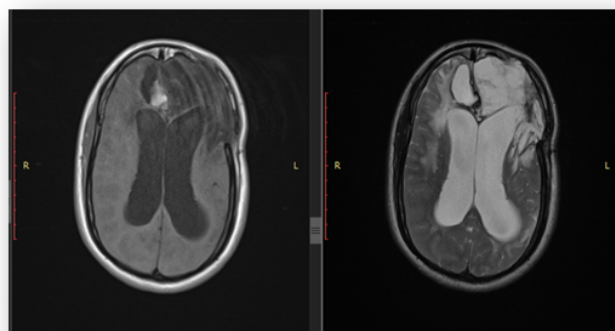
Magnetic Resonance Imaging Study.
